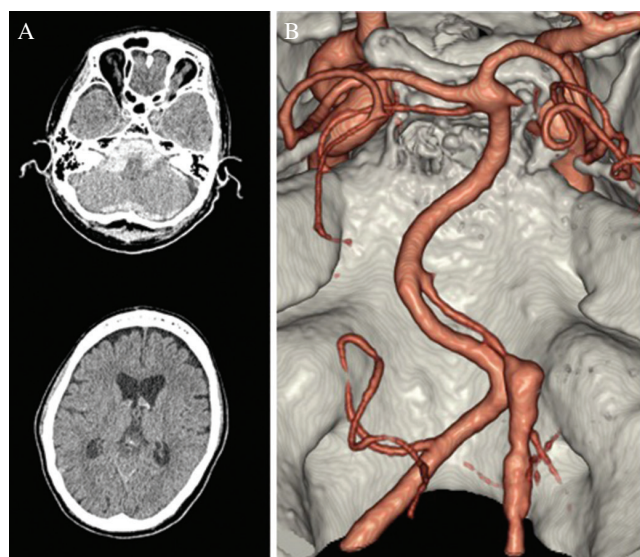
(A) CT shows thick subarachnoid hemorrhage of the posterior fossa. (B) CT angiography reveals the right vertebral artery dissecting aneurysm involving the posterior inferior cerebellar artery (PICA). An aneurysmal dilatation was detected distal to the PICA bifurcation.
